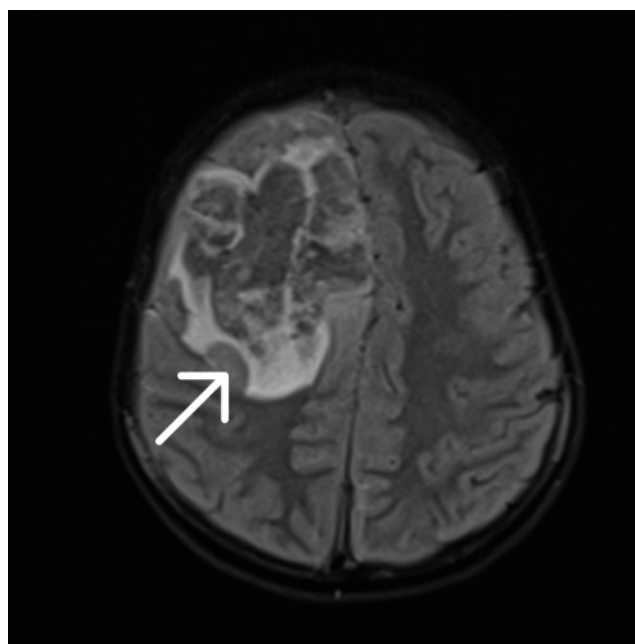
Head MRI with contrast from second day of hospitalization – an extensive and heterogeneous area with various temporal foci of intracerebral haemorrhage and a surrounding zone of oedema measuring $95 \times 60 \times 52$ mm
